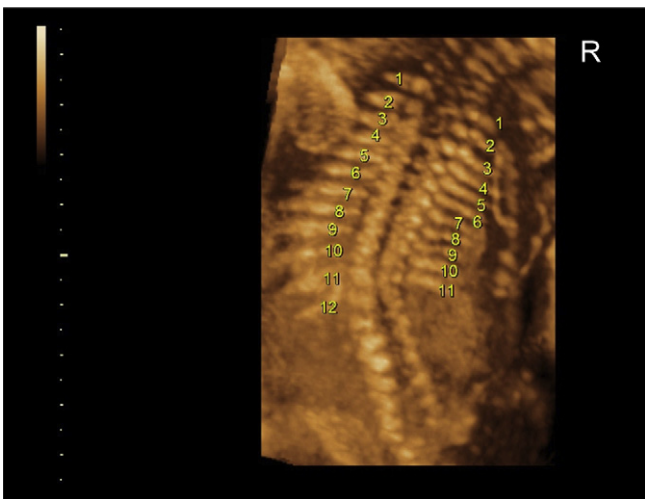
Three-dimensional ultrasound demonstration of scoliosis with absence of one rib.
